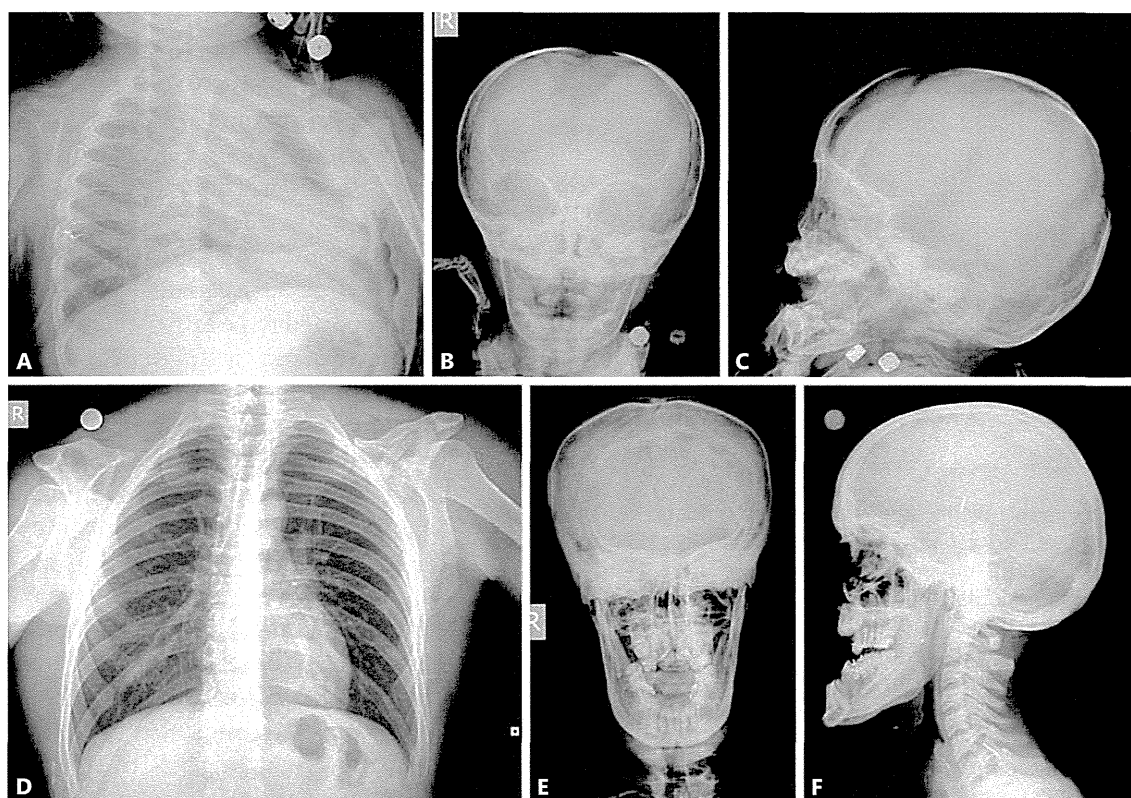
Radiographs of the proband's chest and skull demonstrating the complete absence of bilateral clavicles, open large fontanelles, multiple wormian bones, supernumerary teeth, and mandibular protrusion (A–C). Anteroposterior radiograph of the father's chest demonstrating bilateral absence of clavicles (D) and radiographs of his skull demonstrating multiple wormian bones, a relatively thick skull and prognathism (E, F).
